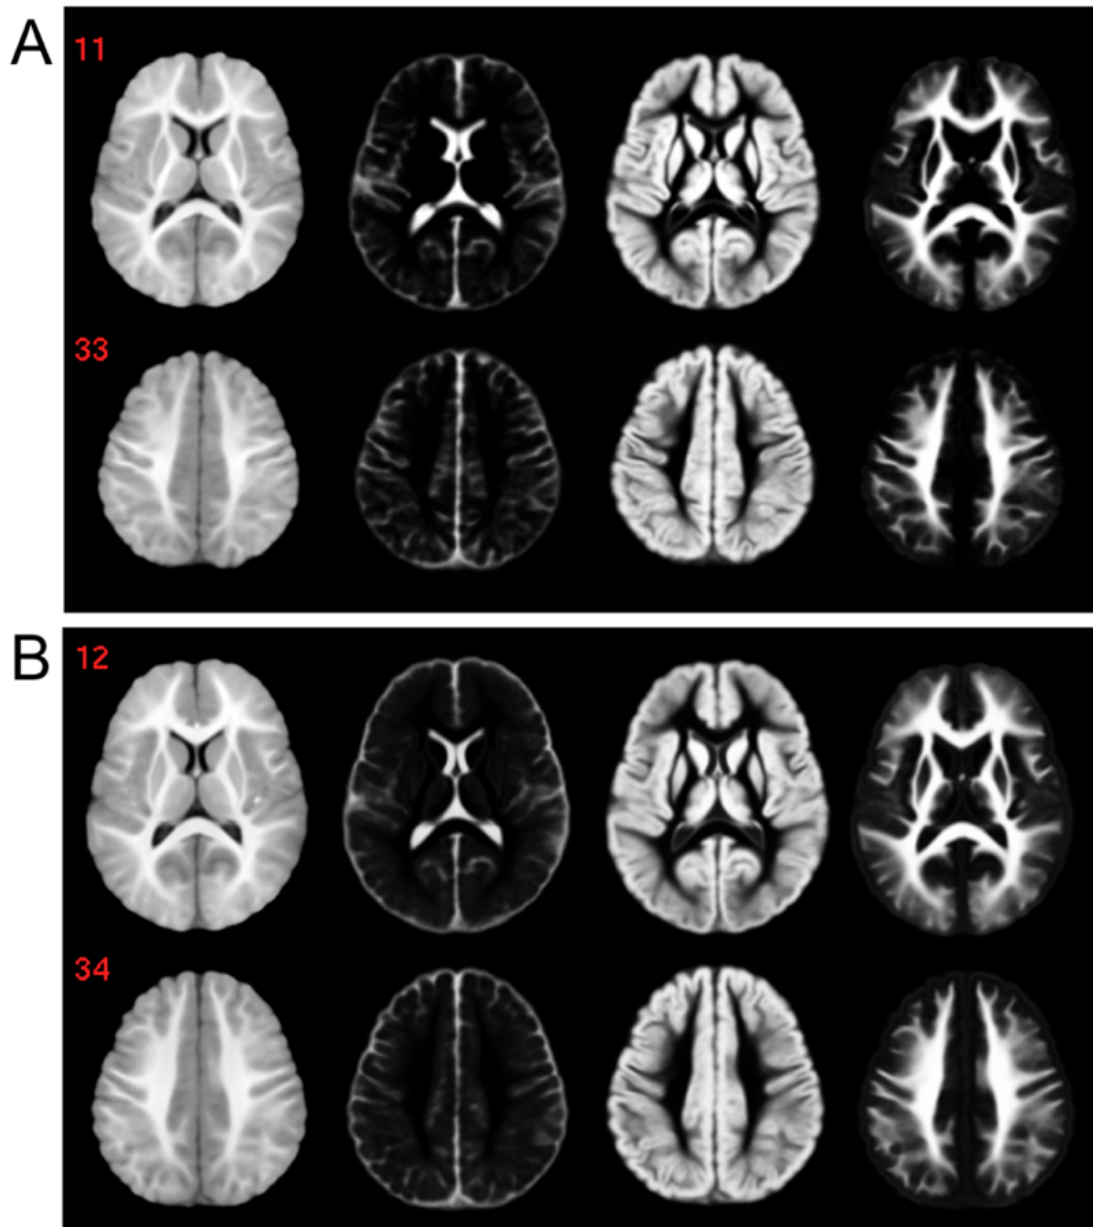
T_1 -weighted averaged MRI data for 12-month-old infants (A) and 24-month-old infants (B). Far left column: T_1 -weighted brain intensity template. Centre left column: CSF tissue probability map. Centre right column: grey matter tissue probability map. Far right column: white matter tissue probability map. Figure adapted from Shi et al. (2011). Copyright 2011 Shi et al., licensed under [CC BY 3.0](https://creativecommons.org/licenses/by/3.0/).
